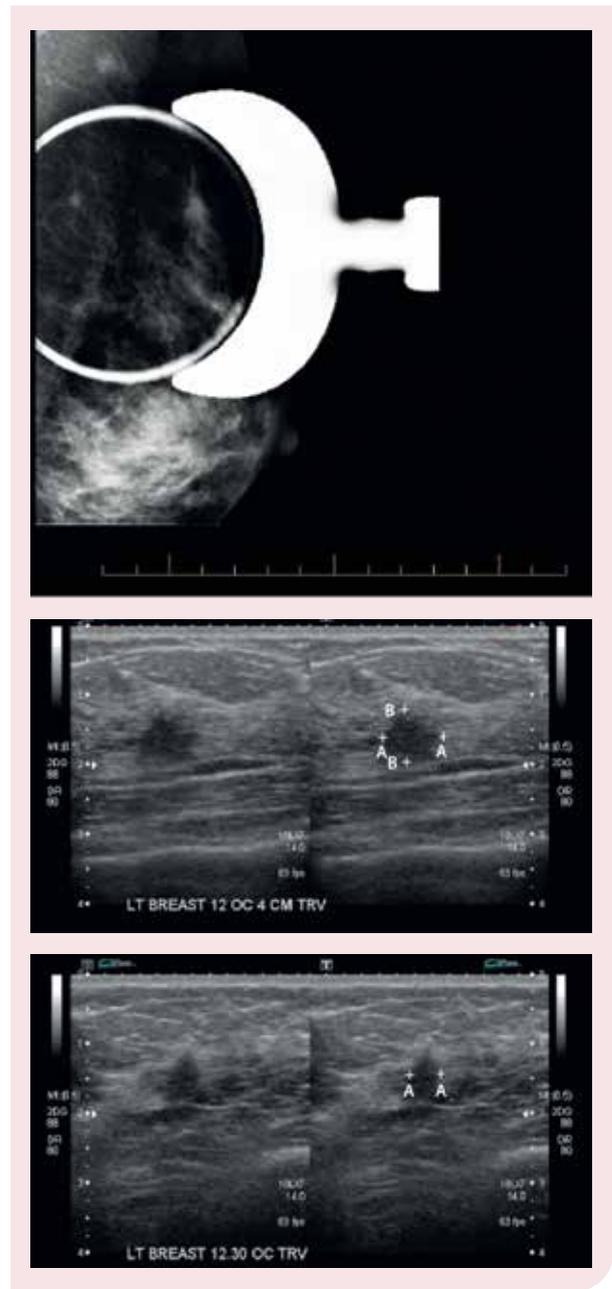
Work-up mammographic view showing two small spiculate masses. In the bottom and middle images, ultrasound also demonstrates two small, ill-defined hypoechoic masses with suspicious features.
